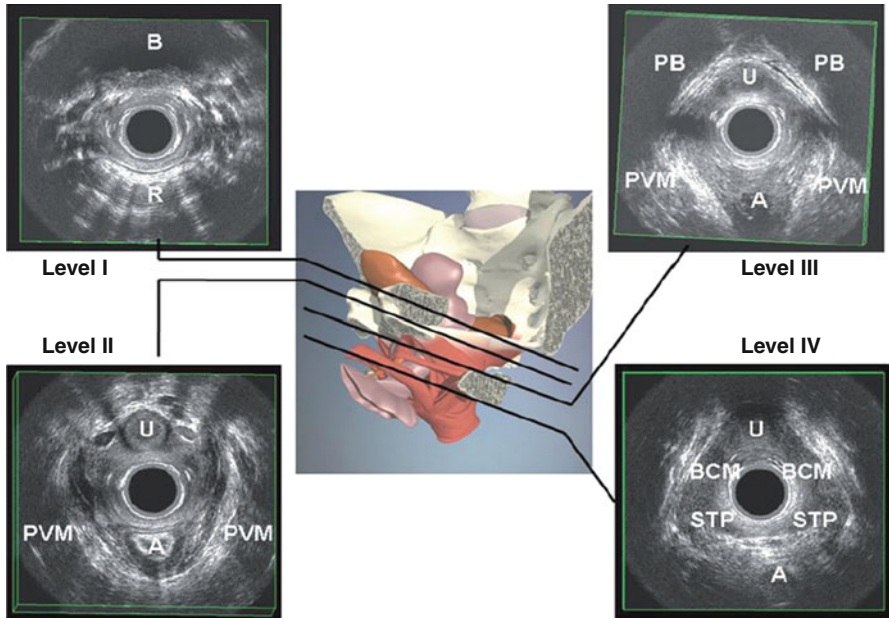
Four levels of assessment of pelvic floor anatomy by using 3D endovaginal ultrasound (see text)
